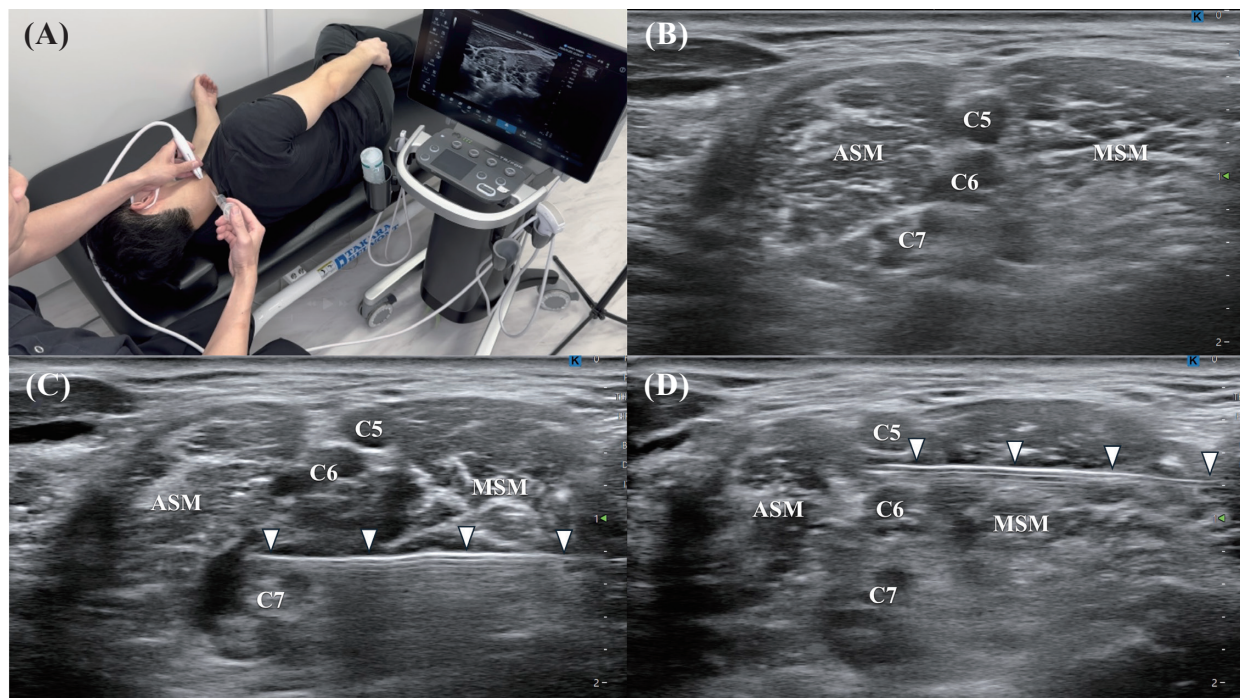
Ultrasound-Guided Cervical Nerve Root Block
